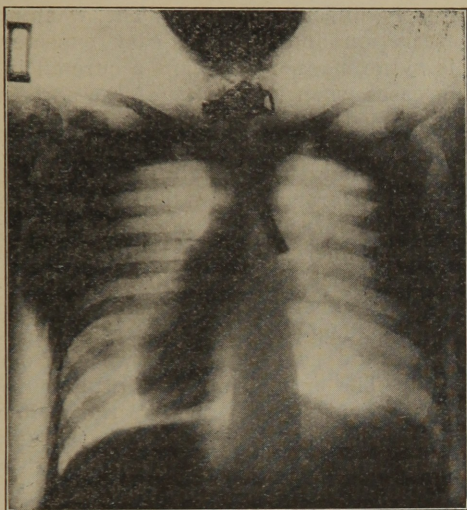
Radiograph of the writer's method of drainage of a bronchiectatic cavity and pulmonary "sponge soaking." A long fenestrated soft rubber tube is used as the inner tube of the tracheal cannula. Little air entered the right lung until the tube opened the stricture and drained the "sponge soaked" area.
